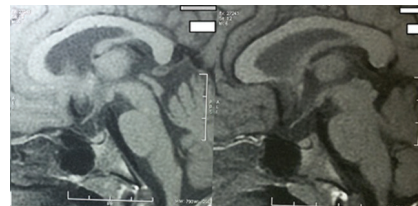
MRI of pituitary region showing absence of posterior pituitary bright spot.
